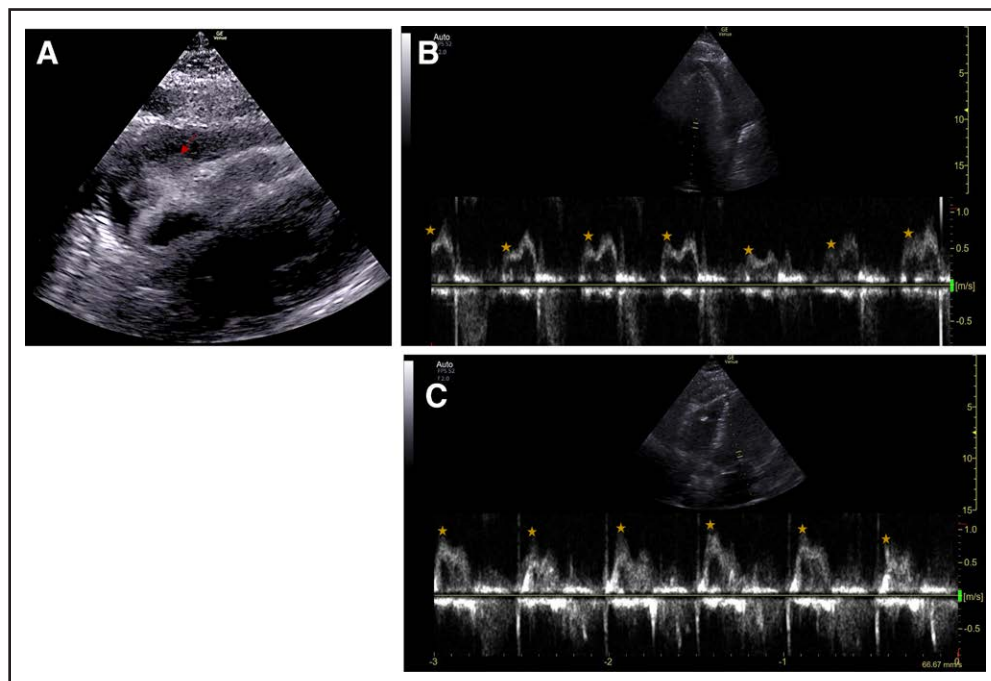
A, Subxiphoid view showing large pericardial effusion (red arrow). B, Pulse wave Doppler showing significant mitral valve inflow variation (> 25%). C, Postpericardiocentesis improvement in mitral valve inflow variation. Gold stars denote peak velocity of figures.
